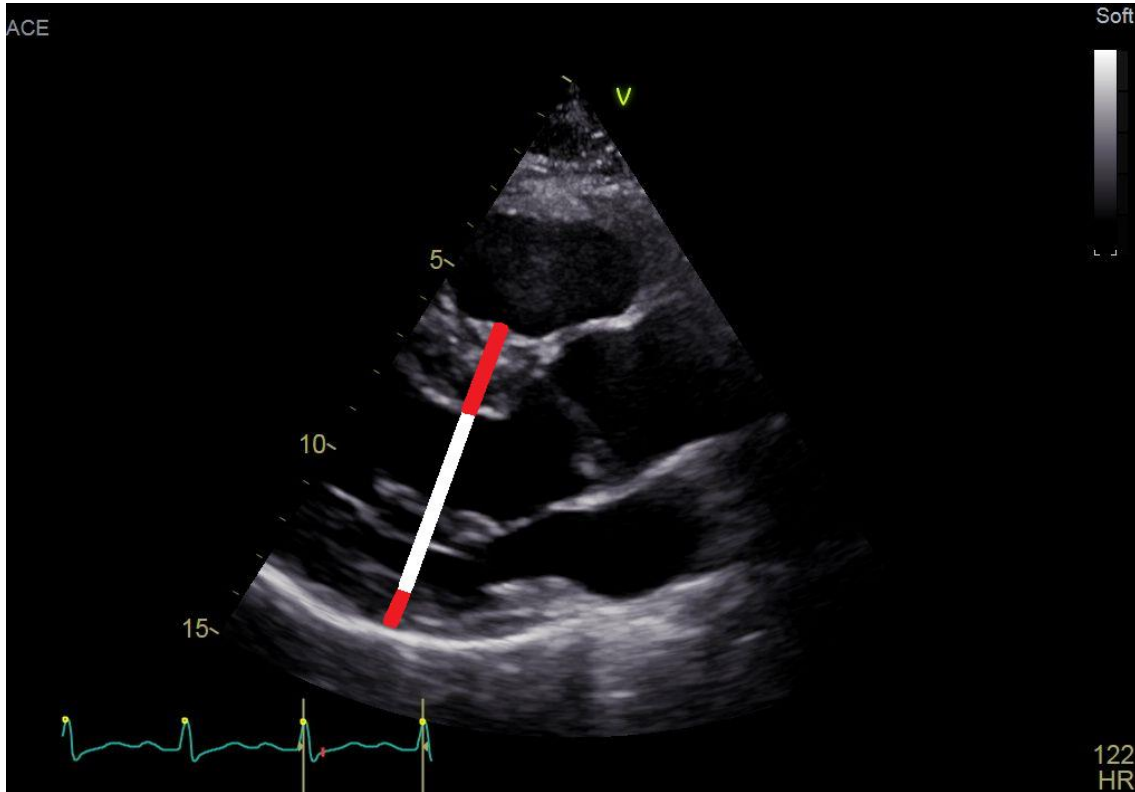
Hypertrophic cardiomyopathy in an athlete. Parasternal long-axis acquisition of a professional soccer player with hypertrophic cardiomyopathy. A screening echocardiography examination found significant left ventricular hypertrophy with a septal predominance (wall thickness: 17 mm, upper red arrow) and high-normal left ventricular end-diastolic diameter (white arrow). Cardiac magnetic resonance showed the absence of cardiac fibrosis; however, suspension of training did not result in regression of the left ventricular hypertrophy confirming the diagnosis of hypertrophic cardiomyopathy.
